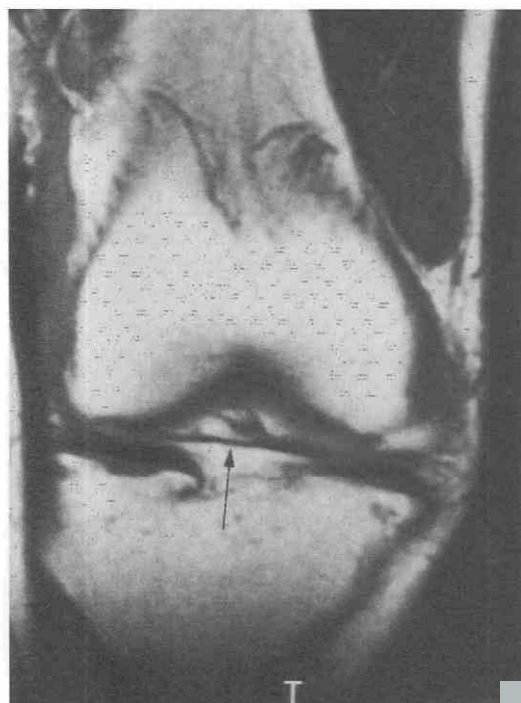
Transverse ligament. Coronal T1-weighted image, far anteriorly, shows the transverse ligament extending from the medial to the lateral compartments of the knee (arrow).
